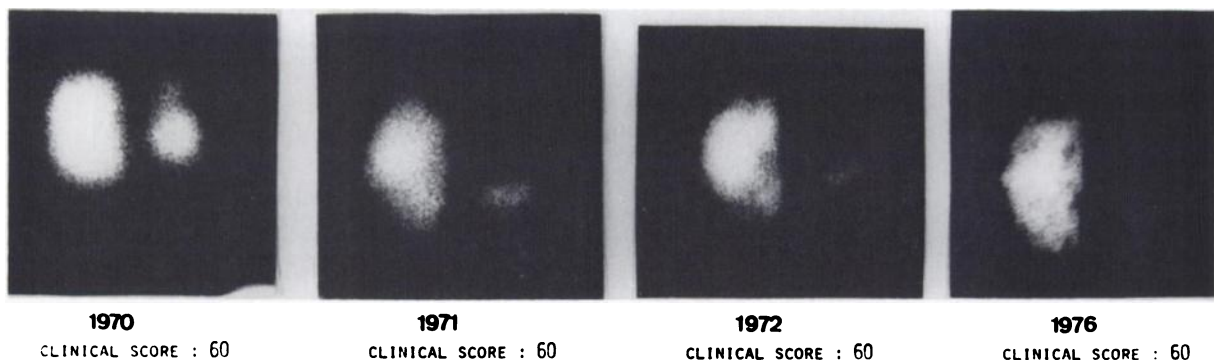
Example of striking scintigraphic deterioration, while clinical score remained unchanged.
